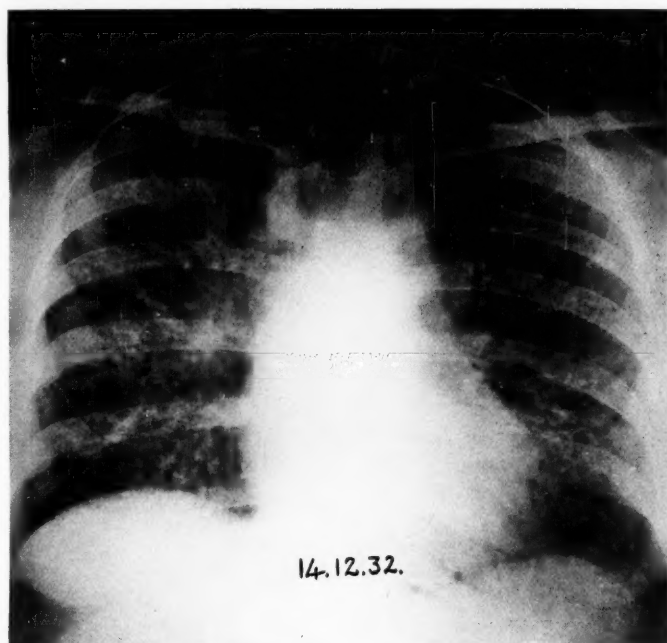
Case 2. X-ray of chest nine months after operation
